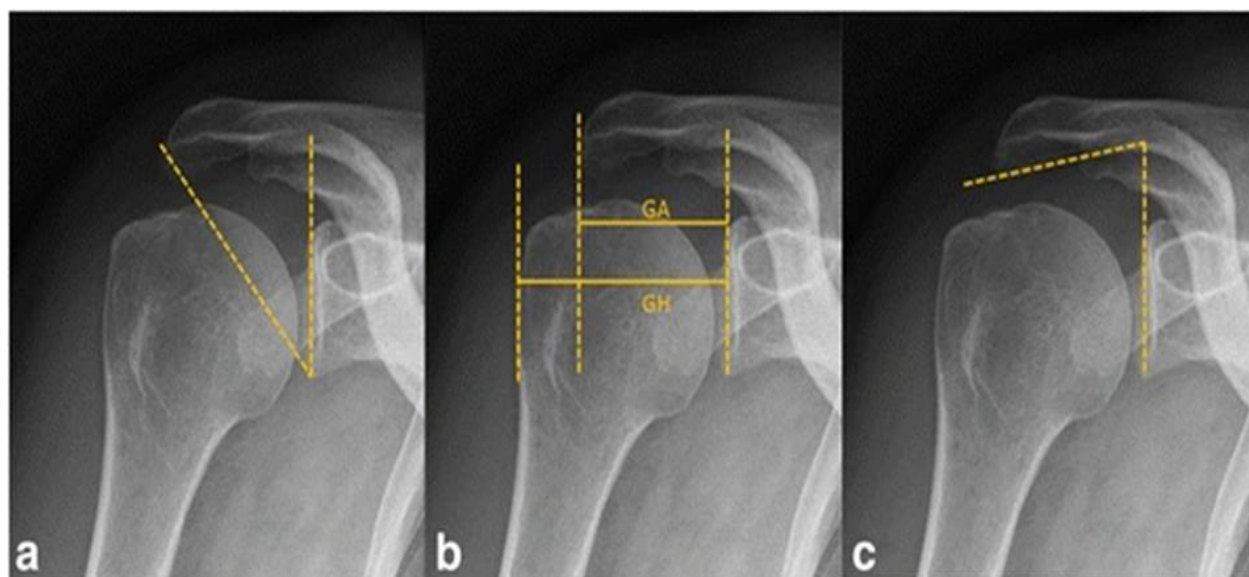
Radiological measurements of critical shoulder angle (CSA), acromion index (AI), and lateral acromion angle (LAA) using AP radiographs
